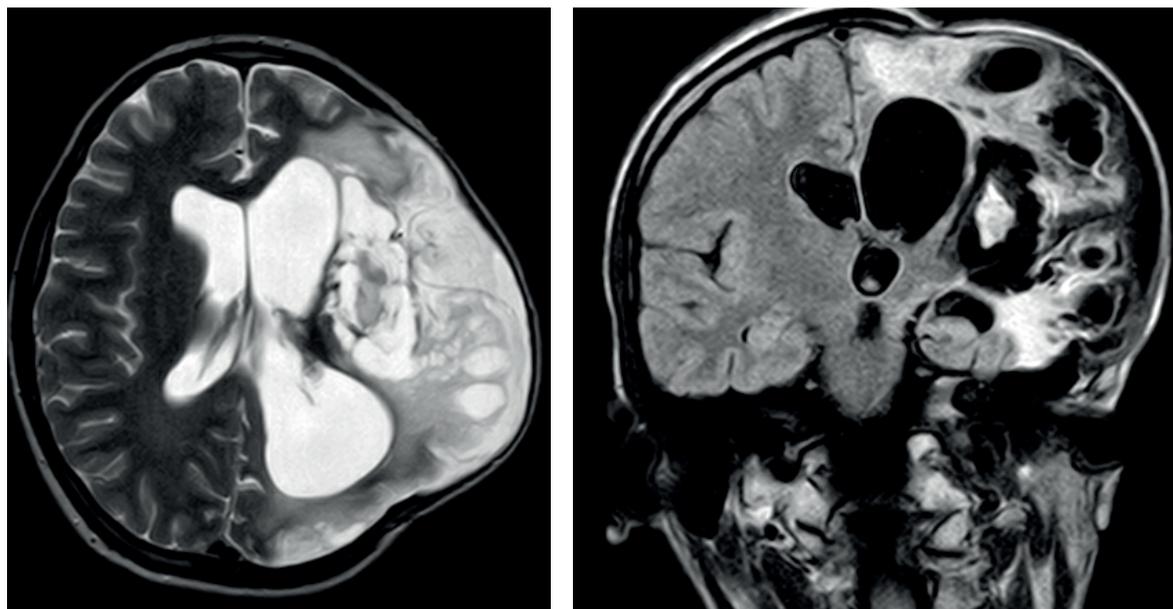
Magnetic resonance imaging of the brain with extensive posts ischemic and postmalaltic changes.
